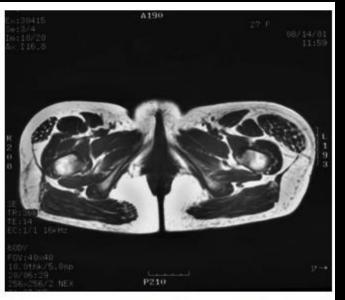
Fifty-nine-year-old male with history of diabetic peripheral neuropathy and multiple surgeries of right foot, presented with left anterior thigh mass. Axial T1-weighted MR(TR:366 TE:14) image of the lower pelvis showed unilateral hypertrophy of the left TFL muscle
